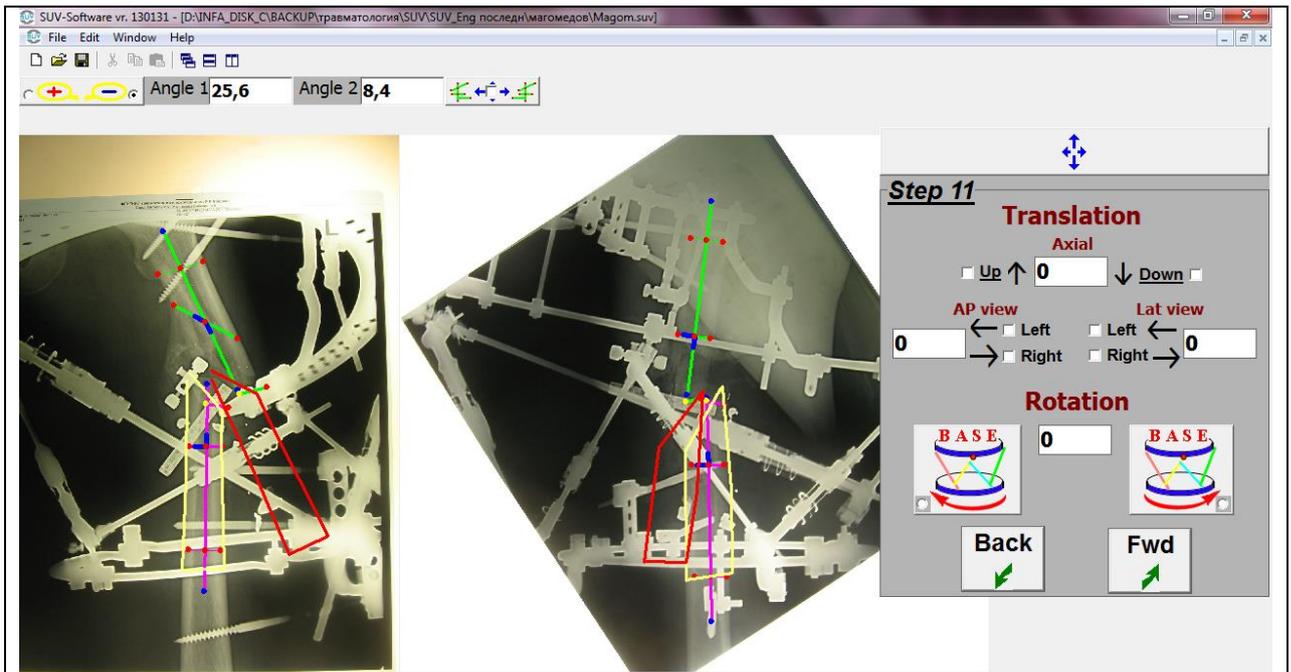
Ortho-SUV program window in Step 11: rotation of mobile fragment. a – value of necessary rotation, 20 deg., is being entered into field "Rotation" (specified by arrow). b - field "rotation to the left" is being ticked. It has resulted to that the form and the sizes of both red bone contours changed
